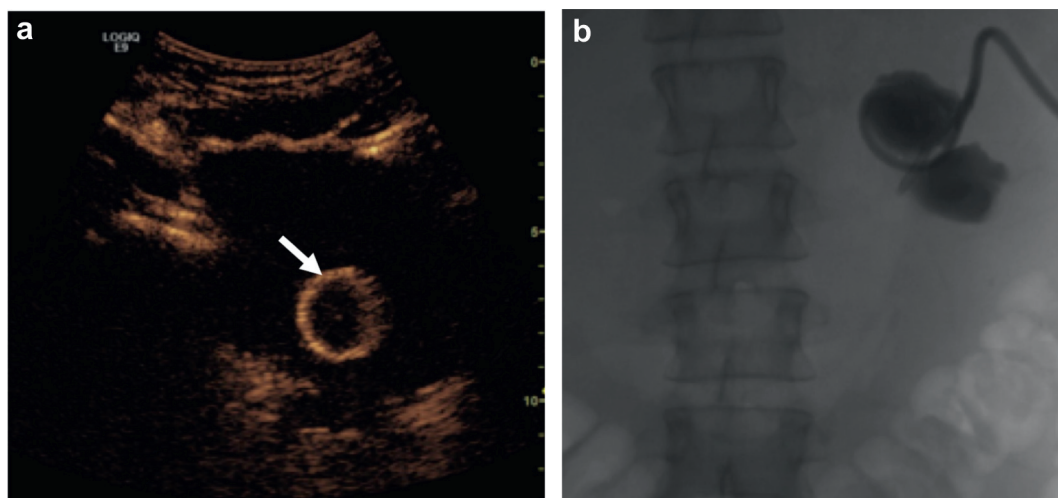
CEUS and fluoroscopic nephrostogram images of 64-year-old female with obstructed collecting system. *a*, 10 minutes after injecting ultrasound contrast agent via preplaced nephrostomy tube CEUS of bladder failed to identify any contrast agent in bladder lumen. Note Foley balloon (arrow). *b*, fluoroscopic nephrostogram confirmed persistent obstruction of left collecting system with no spontaneous flow of contrast material into ureter or bladder.
